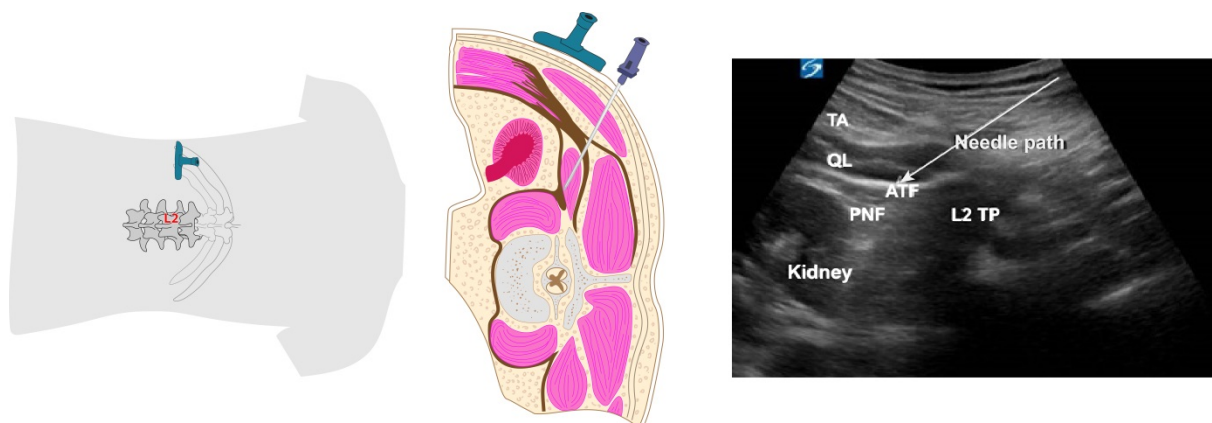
b. Needle pathway view of L2 level ultrasound-guided transmuscular quadratus lumborum block image
